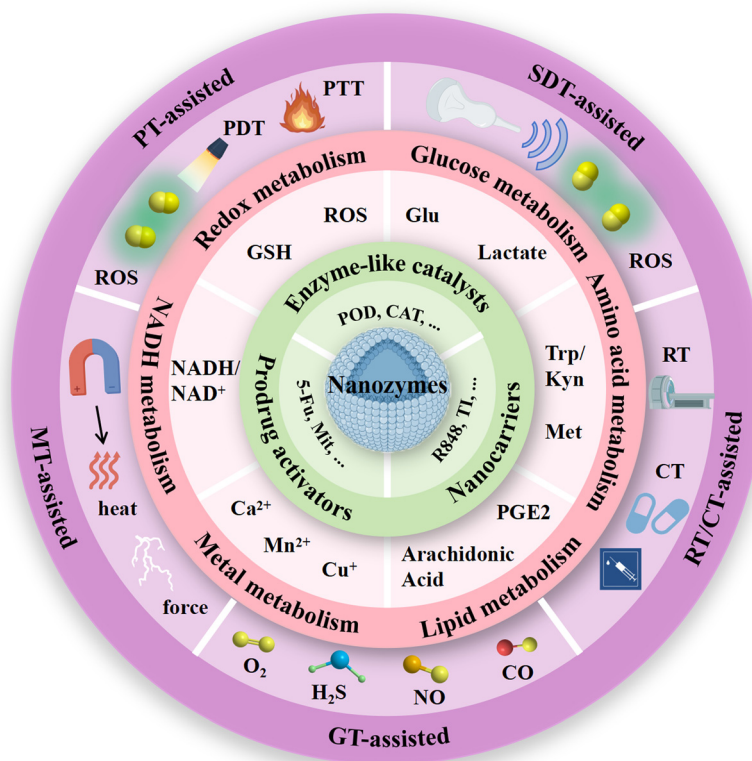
Mechanisms of nanozyme-based treatment strategies for enhanced cancer immunotherapy (By Figdraw). PT, phototherapy; PTT, photothermal therapy; PDT, photodynamic therapy; SDT, sonodynamic therapy; RT, radiotherapy; CT, chemotherapy; GT, gas therapy; MT, magnetic therapy.
